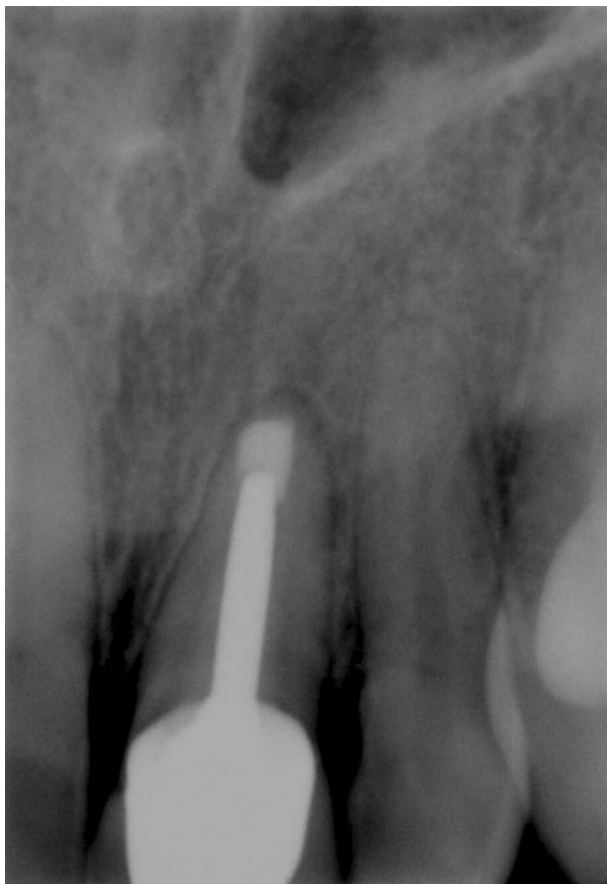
Healing of periapical lesion associated with tooth 21, 6 months after periapical surgery.
